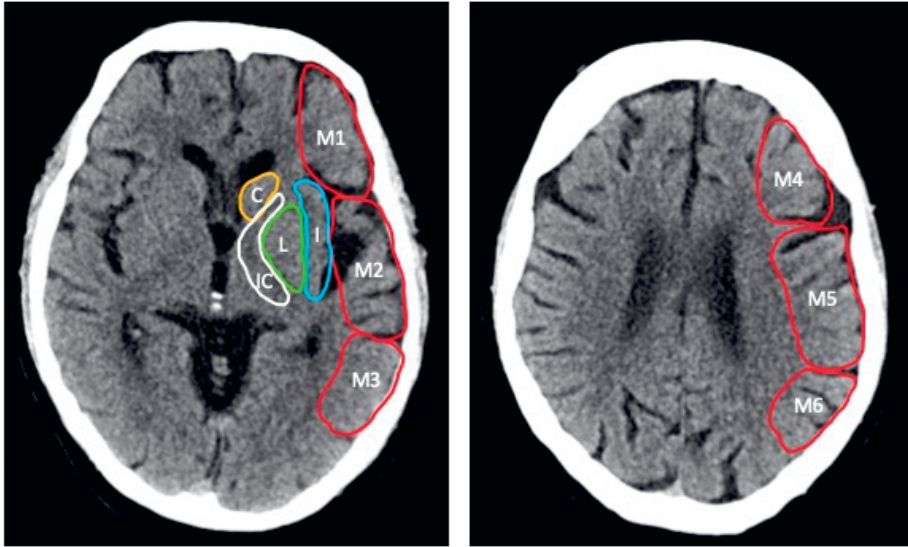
The ten ASPECTS areas in the estimation of an MCA circulation infarct: C (yellow) = nucleus caudatus; IC (white) = capsula interna; L (green) = nucleus lentiformis; I (blue) = insular ribbon; M1-6 (red) = cortical MCA areas.
